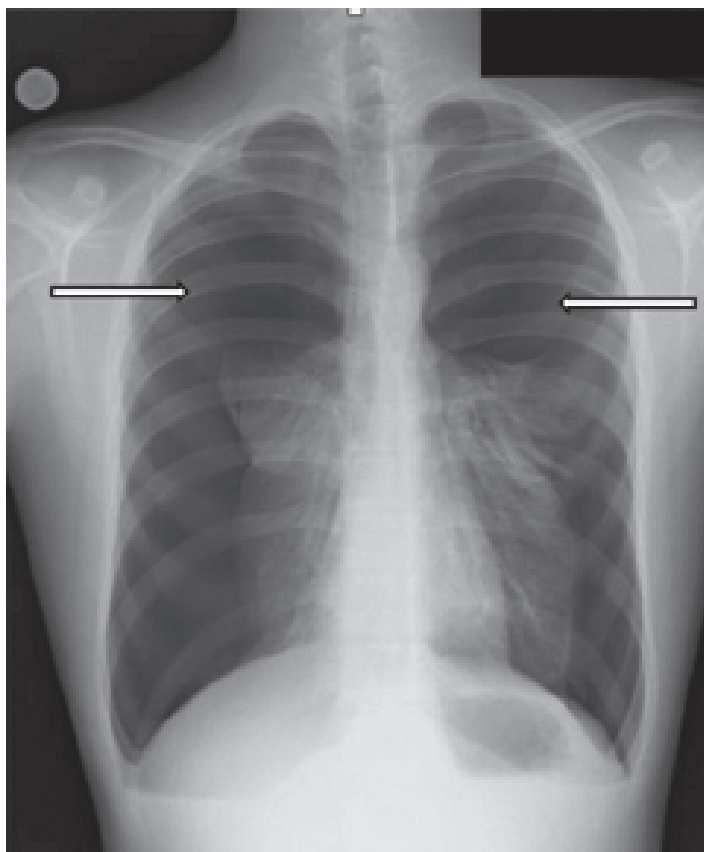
Postero-anterior radiograph of the chest shows near complete bilateral pneumothorax without evidence of pneumomediastinum, pneumopericardium, or subcutaneous emphysema.
